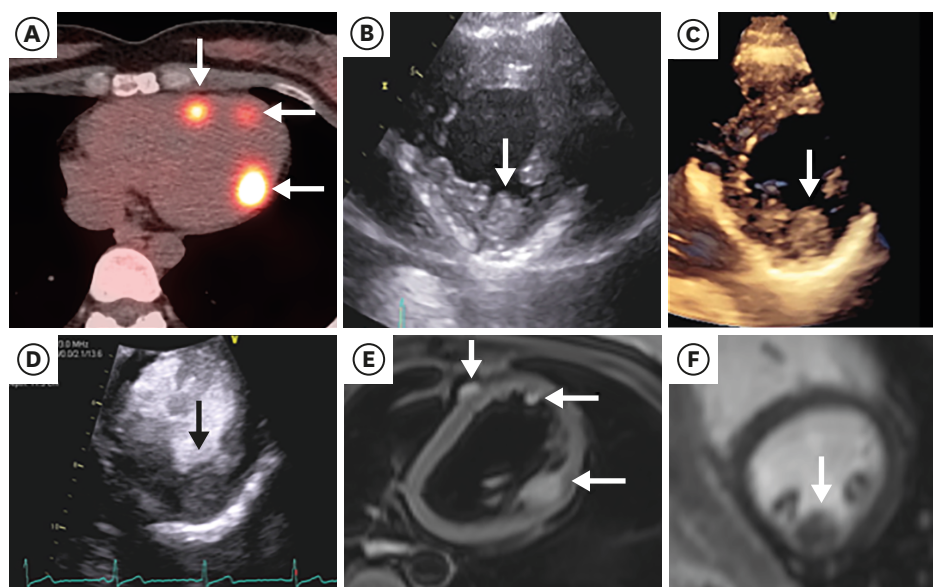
Myocardial metastasis of neuroendocrine tumor. (A) A Gallium-68 DOTATATE PET/CT hybrid image demonstrating radiotracer uptake in the heart (arrows). (B) Transthoracic images demonstrating large echogenic mass (arrow) along the inferolateral wall of the LV. (C) Three-dimensional image confirming presence of large mass (arrow). (D) Contrast-enhanced echocardiographic image demonstrating minimal contrast uptake indicating minimal vascularity (arrow). (E) Turbo spin T2 sequence demonstrating multiple high T2 signal along the LV and RV wall correlating well with Gallium-68 DOTATATE PET images (arrows). (F) There is minimal late gadolinium enhancement on the cardiac MRI (arrow).
